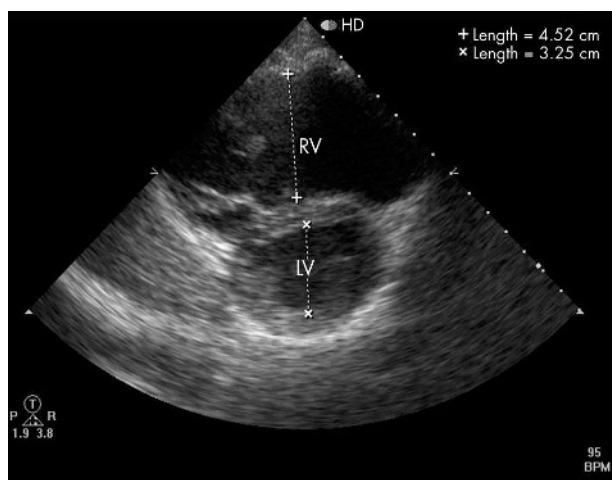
Two dimensional transthoracic echocardiogram, left parasternal short axis view. There is RV dilatation and hypertrophy in a young adult patient with an ostium secundum ASD and a Qp/Qs of 3.2. The left ventricle is “squashed” by the dilated RV. LV, left ventricle; RV, right ventricle.
